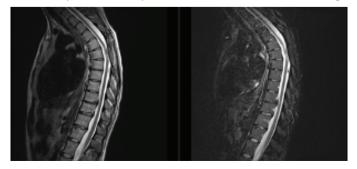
Follow-up T1 and T2-weighted MRI images of second case MRI: Magnetic resonance imaging
